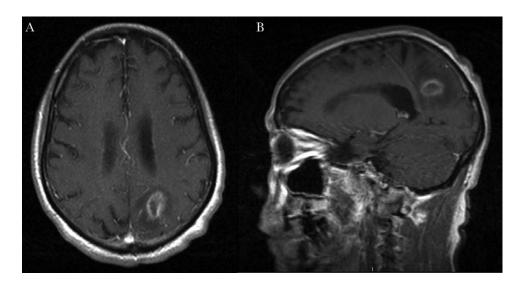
Magnetic resonance imaging of the brain (axial plane [A] and sagittal plane [B]) showing a ring-enhancing 2.2-cm mass in the left parietal occipital lobe with surrounding edema.
